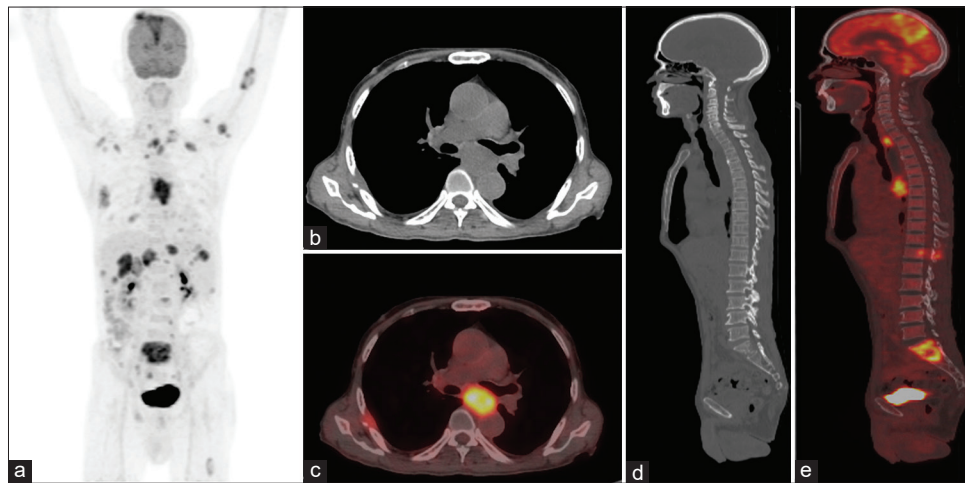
Case of 70-year-old male who presented with dysphagia and upper gastro intestinal endoscopy and subsequent fine-needle aspiration cytology revealed squamous cell carcinoma. The patient was referred for baseline staging in FDG Positron emission tomography/computed tomography and MIP (a), Axial computed tomography (b), Axial positron emission tomography/computed tomography (c), Sagittal computed tomography (d) and Sagittal positron emission tomography/computed tomography (e) are shown. While positron emission tomography/computed tomography played a minimal role in assessment of primary disease (b and c) in terms of local extent and regional lymphadenopathy; it was much superior to other modalities in detection of distant metastases. This was especially significant in this patient where there was a single paratracheal lymph node and no pulmonary metastases. The positron emission tomography/computed tomography was able to identify extensive distant metastases to axial and appendicular skeleton (a, d and e)
